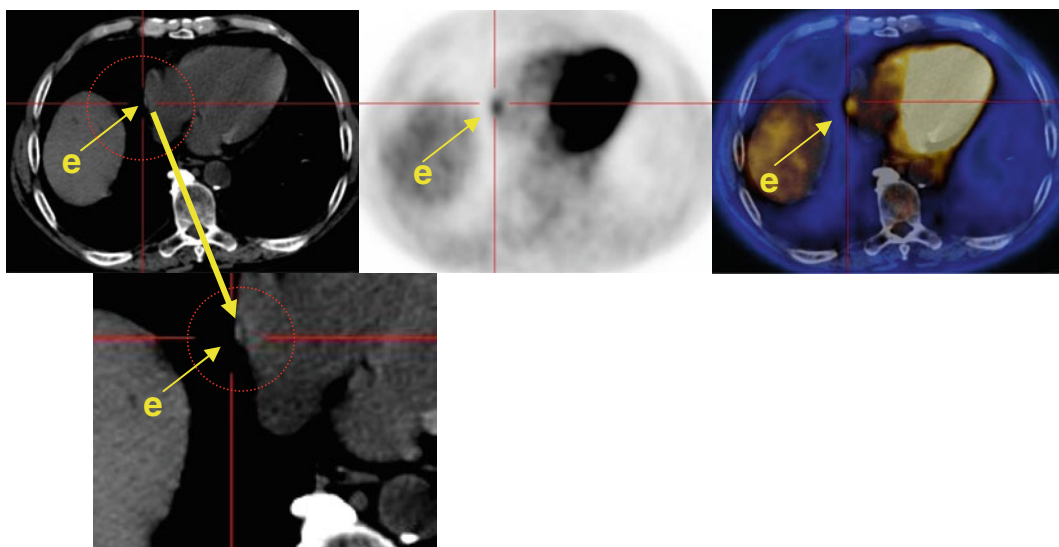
Millimetric nodule at the right diaphragmatic pleura, with pathological metabolism, SUV max 1.1
